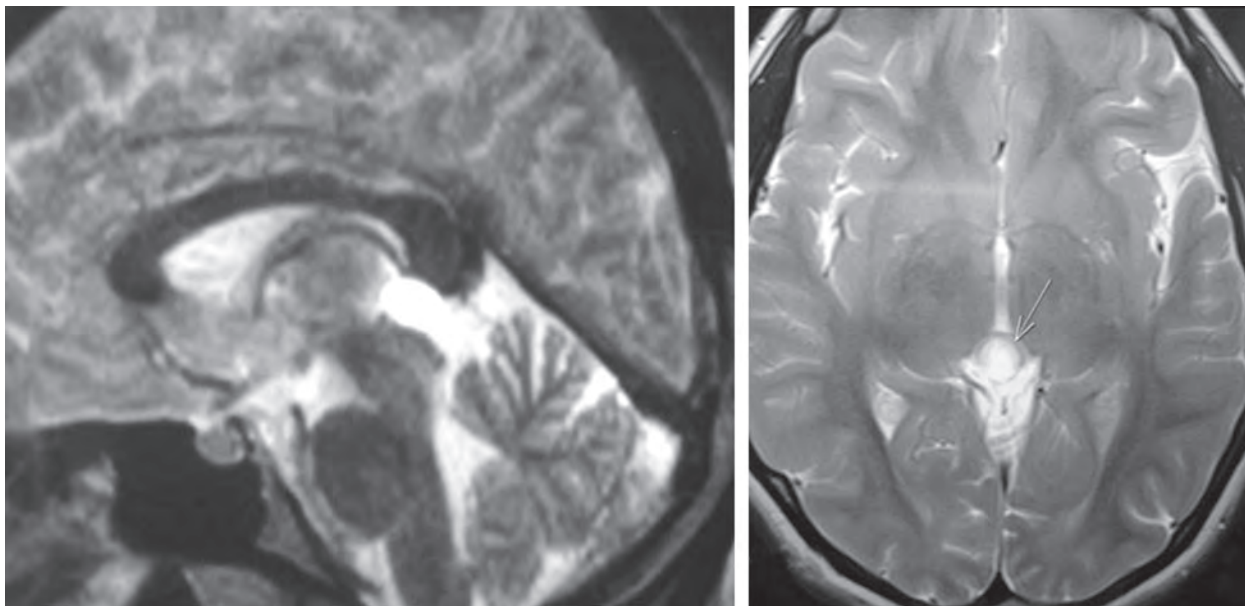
MRI of an asymptomatic pineal cyst in a 17-year-old girl
